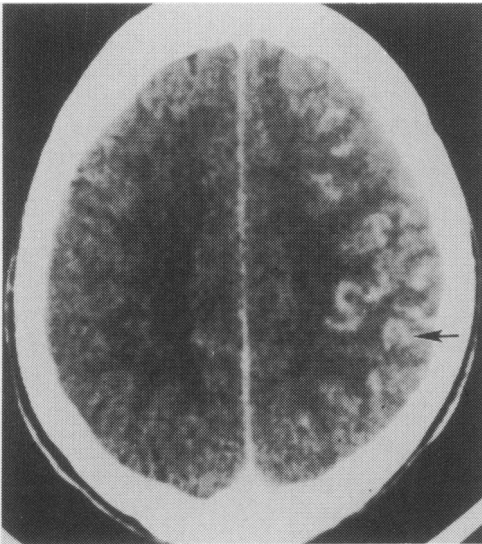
CT scan following intravenous contrast showing dilated vessels in right cerebral hemisphere (short arrow).
